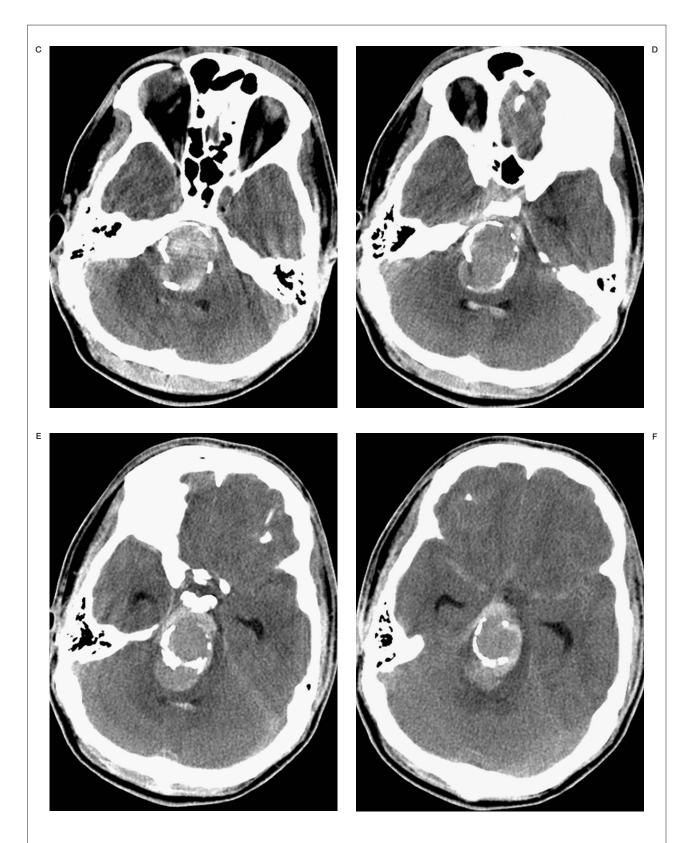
Noncontrast Head CT: Large, irregular, posterior fossa lesion with rim calcification, and partial thrombosis (A-F). Evidence of subarachnoid hemorrhage is seen within the basal cisterns with early ventriculomegaly (E,F). A small amount of intraventricular hemorrhage is seen within the fourth ventricle (C-E).
